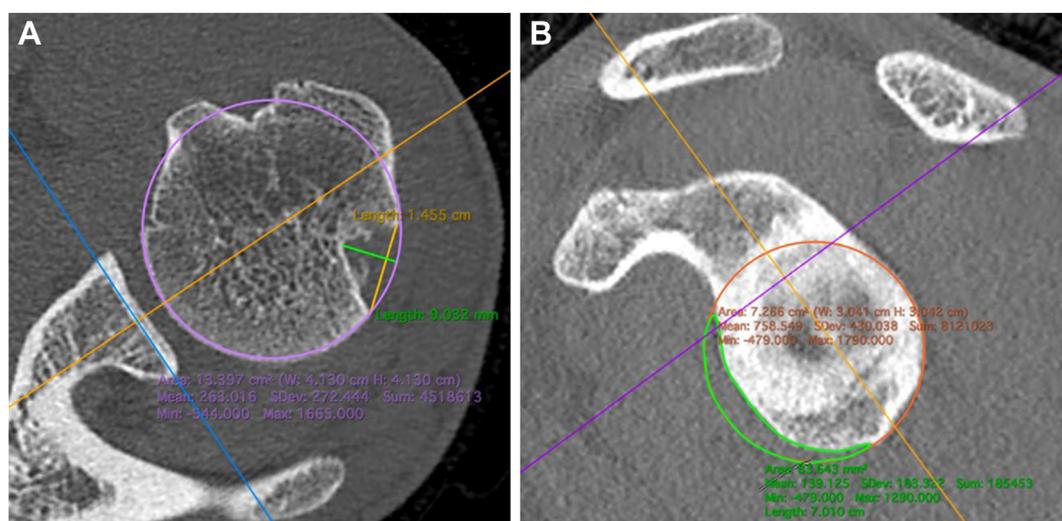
(A) CT scan analysis of humeral bone loss (axial section view). According to the method of Cho et al.²³ In this example, the depth of the Hill-Sachs lesion is 9.032 mm, the width of the lesion is 14.55 mm and humeral head diameter is 41.30 mm. (B) CT scan analysis of glenoid bone loss (sagittal section view). According to the method of Sugaya et al.²⁴ In this example, the total glenoid area is 726.6 mm² and the total bone substance loss area is 83.64 mm².
